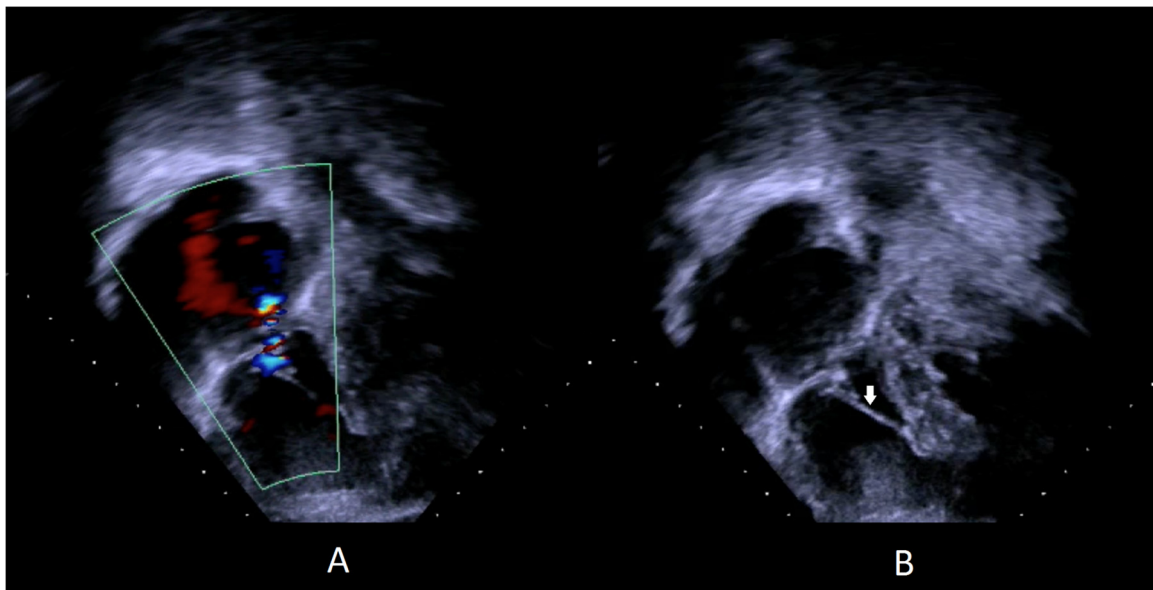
A) Postoperative echocardiography showing the repaired tricuspid valve with mild tricuspid insufficiency with color Doppler; B) Postoperative echocardiography showing the synthetic chordae (arrow).
